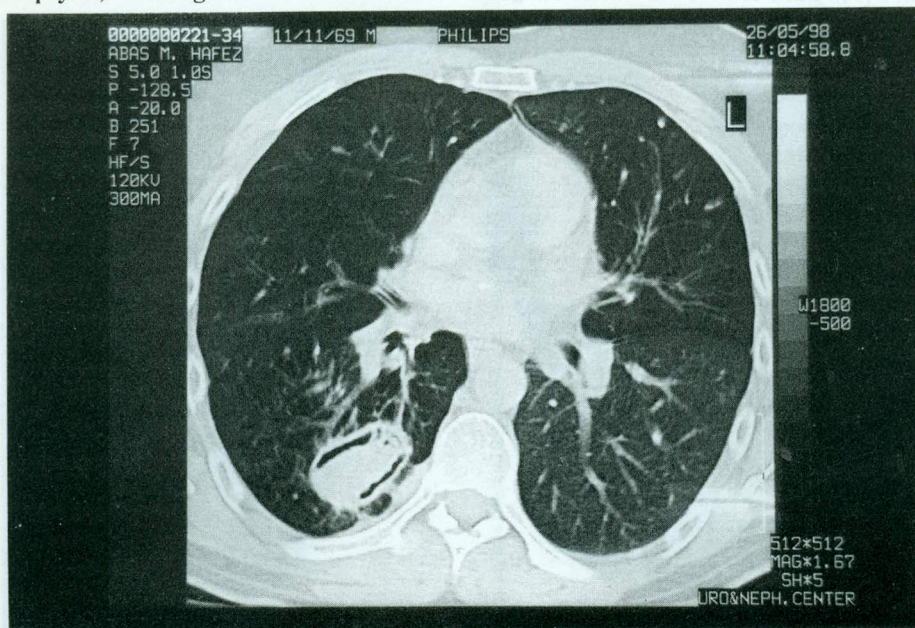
Case 1: a CT scan reveals a TB cavity with a mycetoma inside it. In the apical segment of right lower lobe.
